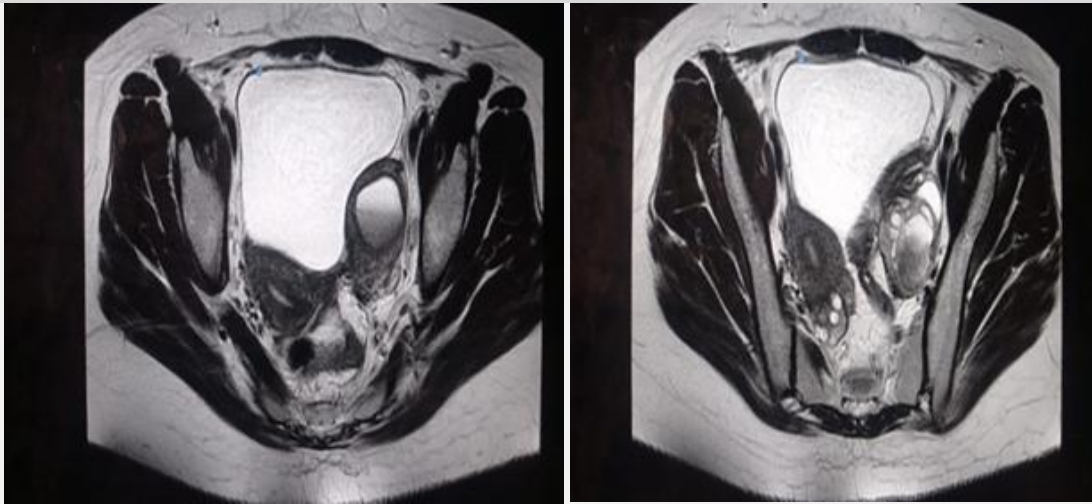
MRI of the pelvis. (A) right horn with normal zonal anatomy and left haematometra. (B) The normal right uterine horn, and, mild left hematosalpinx
